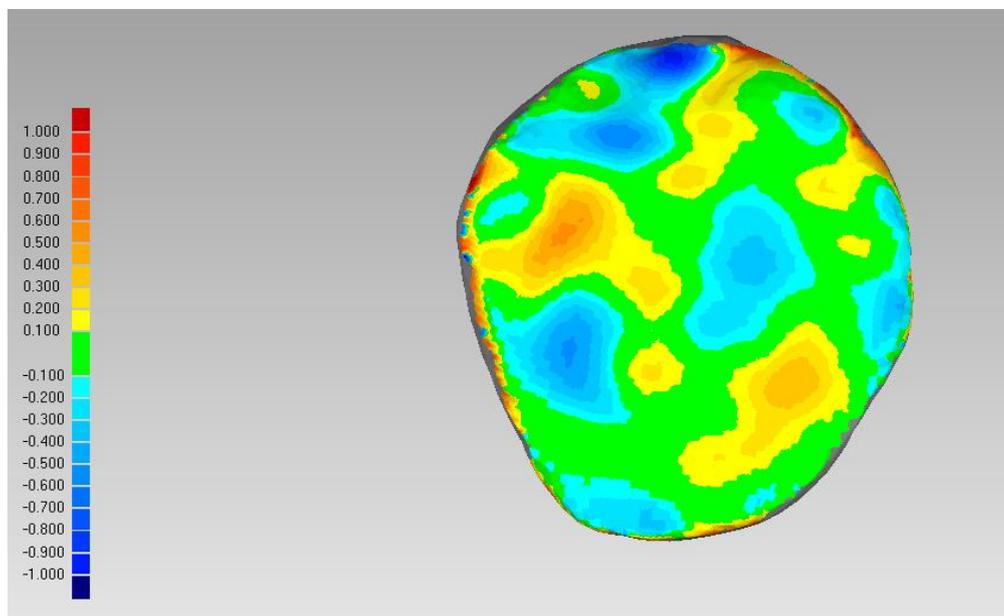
Top view of the colour deviation map for the spatial distribution of the deviations between the reference (MRI) and the test (laser) model of a left tibial lateral cartilage
